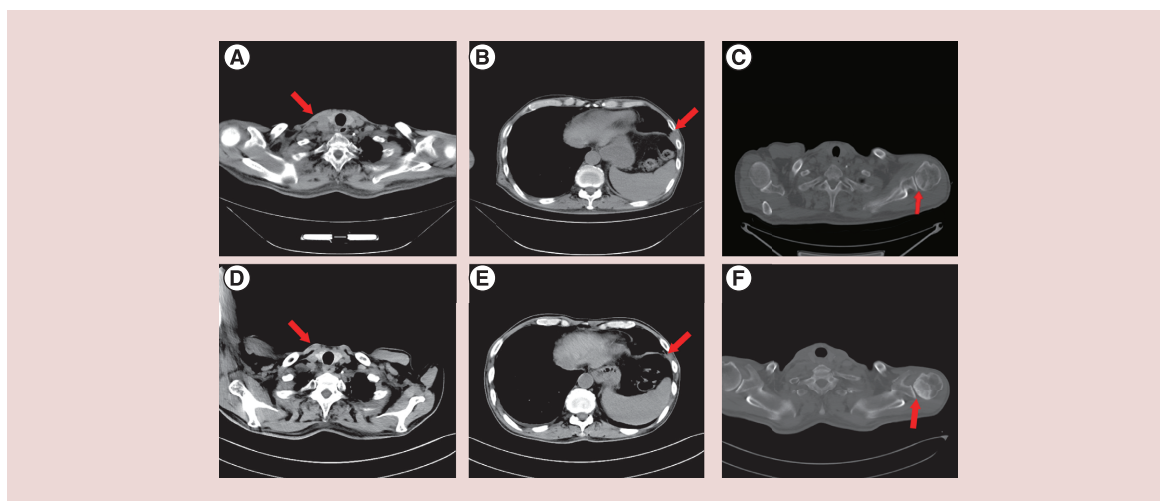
Response of the main lesion estimated by computed tomography. (A–C) CT scan shows multiple lymphadenopathies around the right supraclavicular soft tissue, pleural mass in the left anterior inferior wall and an osteolytic destruction of the left humeral head. Arrows in figures indicate the position of lesions. (D–F) The supraclavicular lymph node and pleural mass in the left anterior inferior were significantly reduced after three cycles. The osteolytic bone destruction of the left iliac bone became osteogenic.
